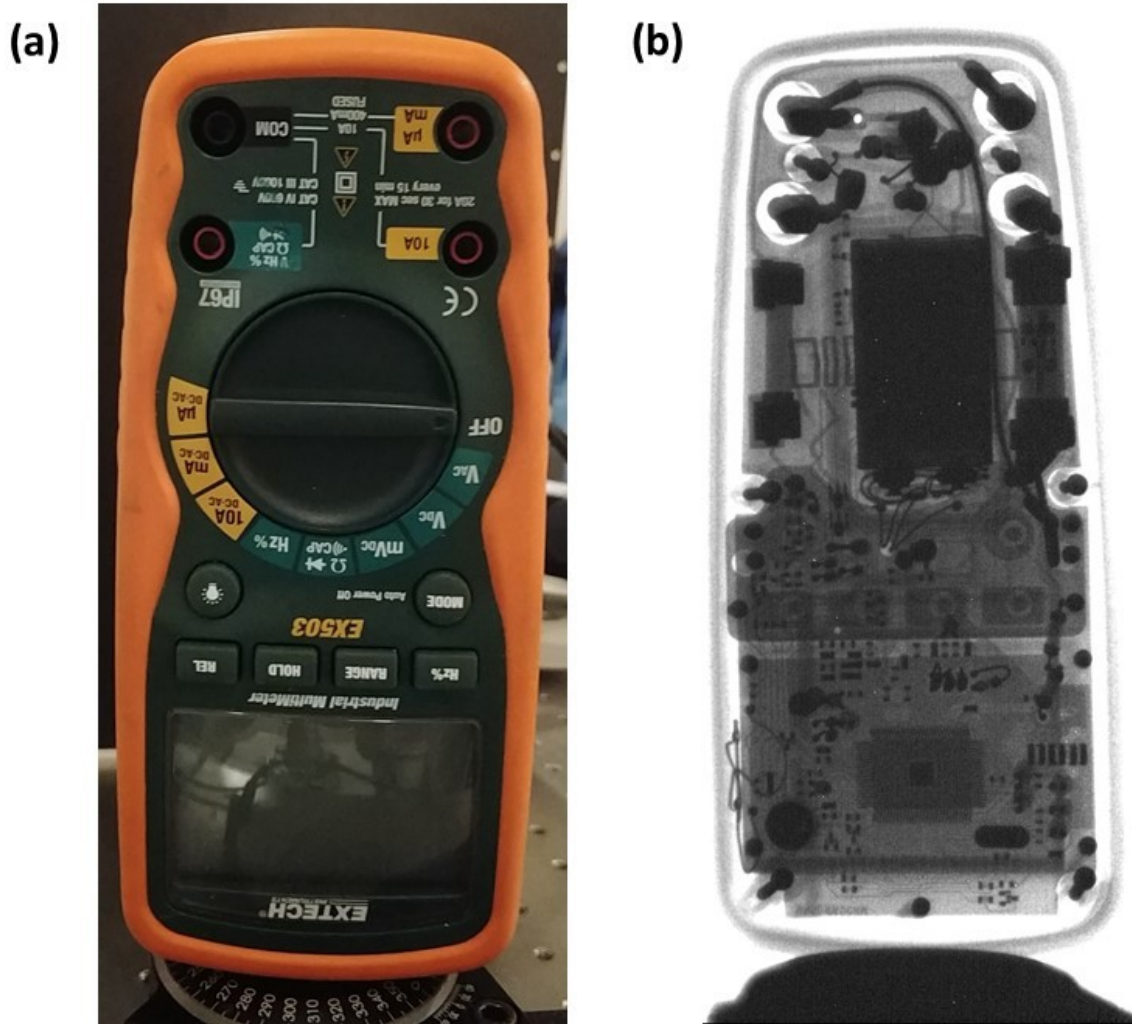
(a) Optical and (b) 2D x-ray image of a multimeter taken using a  $1000 \times 1000 \mu\text{m}^2$  source at 38 kVp with a pulse width of 200 ns,  $V_G = 57 \text{ V}$  and a period of 20  $\mu\text{s}$ . The total exposure time was 1s or 50000 pulses
